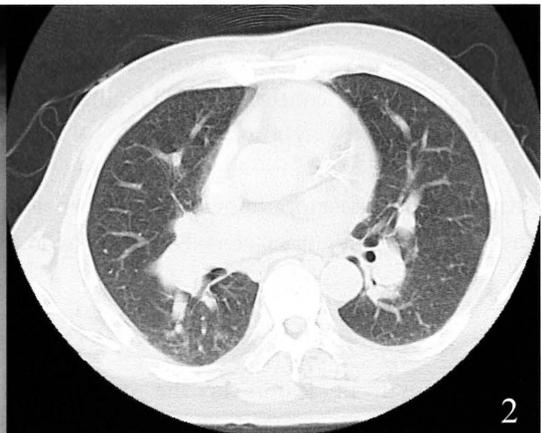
Thoracic CT revealed marked enlargement of bilateral hilar pulmonary arteries and venous dilatation appearance in the peripheral lung fields.
